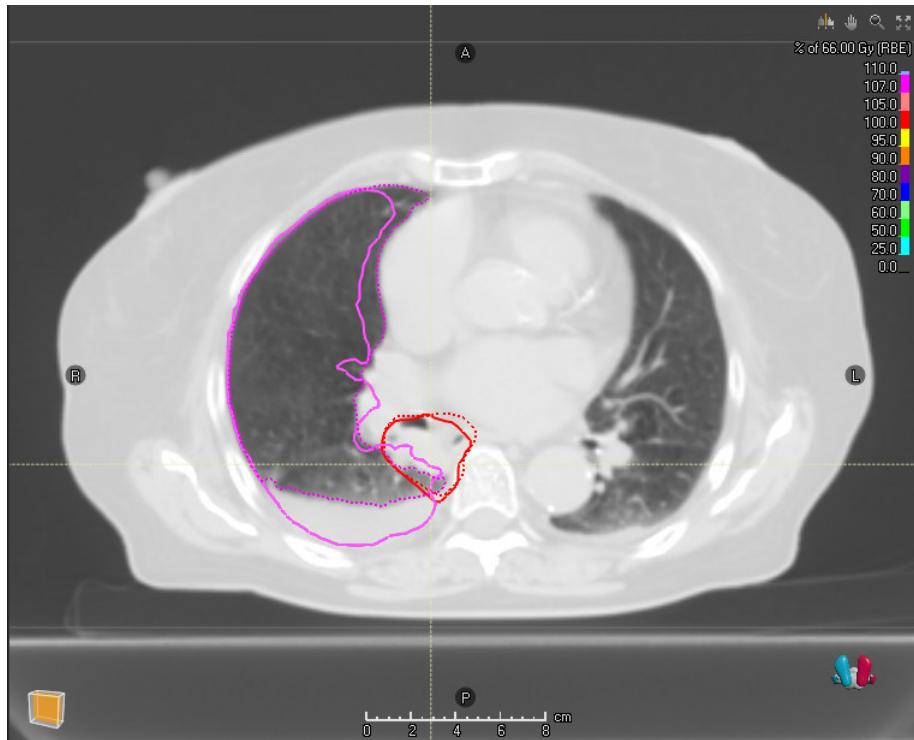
Single CT 2 slice for patient 12 showing physical changes in the lung from CT 1 to CT 2 (solid pink line shows how lung delineation in CT 1).
